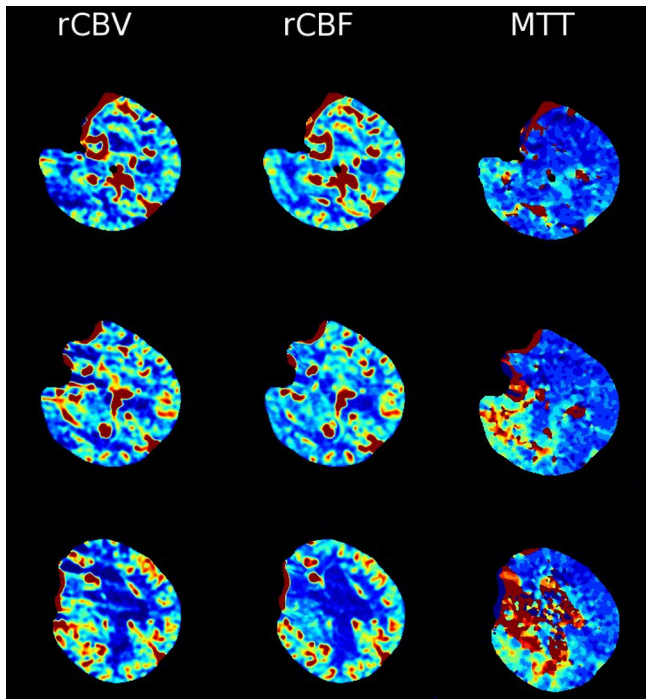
CT perfusion performed as part of the initial diagnostic evaluation shows a large area of delayed mean transit time (MTT) in the right temporoparietal region. Cerebral blood volume (CBV) and flow (CBF) are largely preserved and symmetric compared with the left, suggesting a large penumbra.
